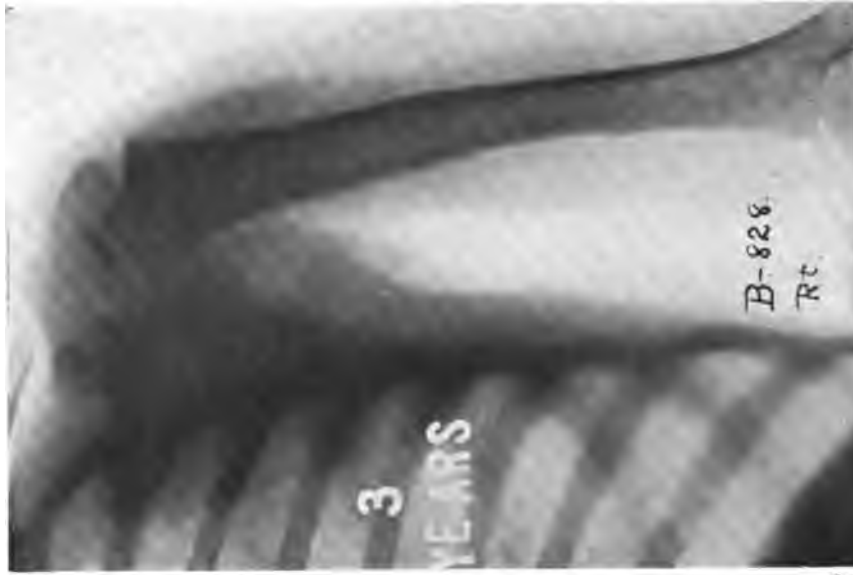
Case 1. At the end of the third year roentgenograms of the injured and the uninjured humeri revealed little disparity. The bones were of the same length, functions of both arms were normal in every way, while the injured bone still presented a suggestion of outward curvature, insignificant when compared with the original extreme deformity. (Roentgenogram transposed by use of screen.)
